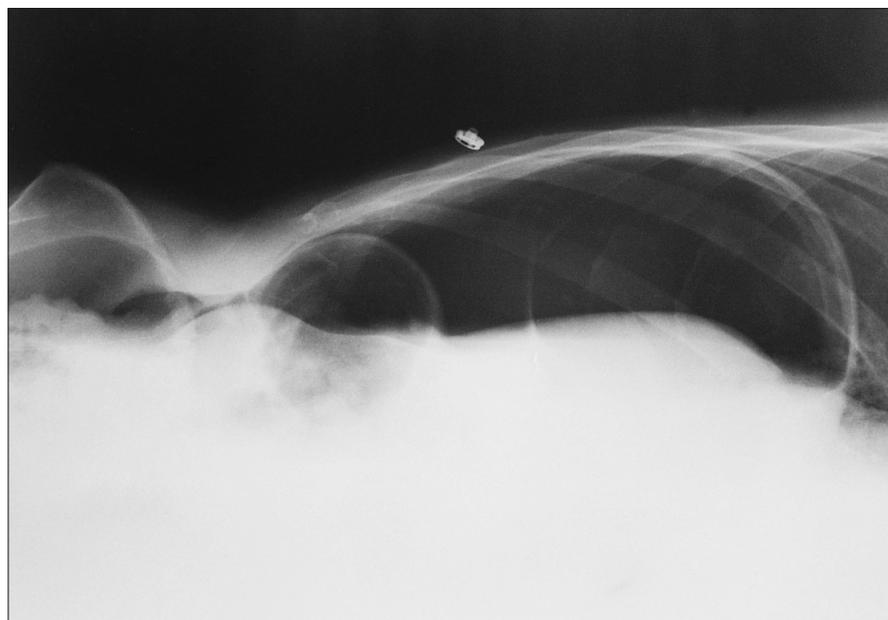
Decubitus abdominal roentgenogram shows large amount of free air displacing liver.
